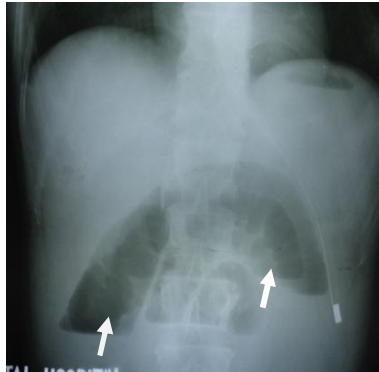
Plain X-ray Abdomen
